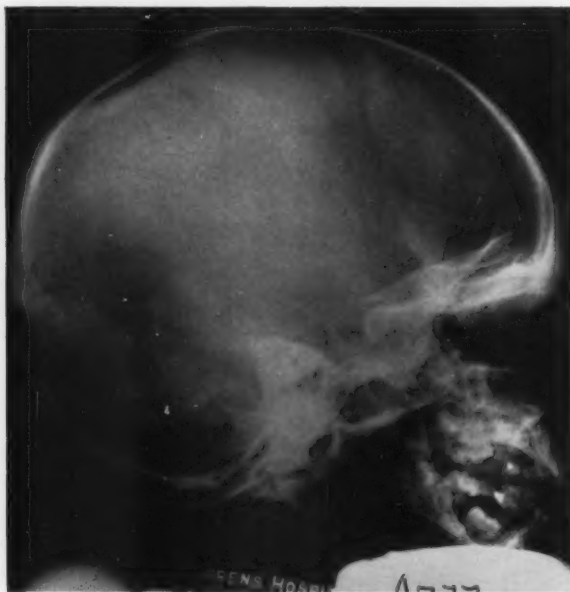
Case 2. W. E. Skull lesions have almost completely filled in. X-ray taken one month before death.
